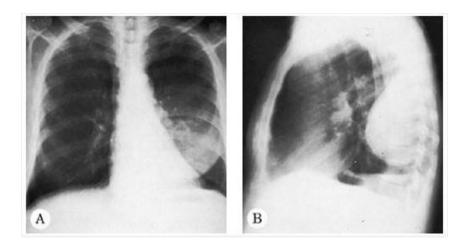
A] Posteroanterior radiograph of patient with encapsulated pleural effusion. B] Inverted D or pregnant lady sign on lateral view
